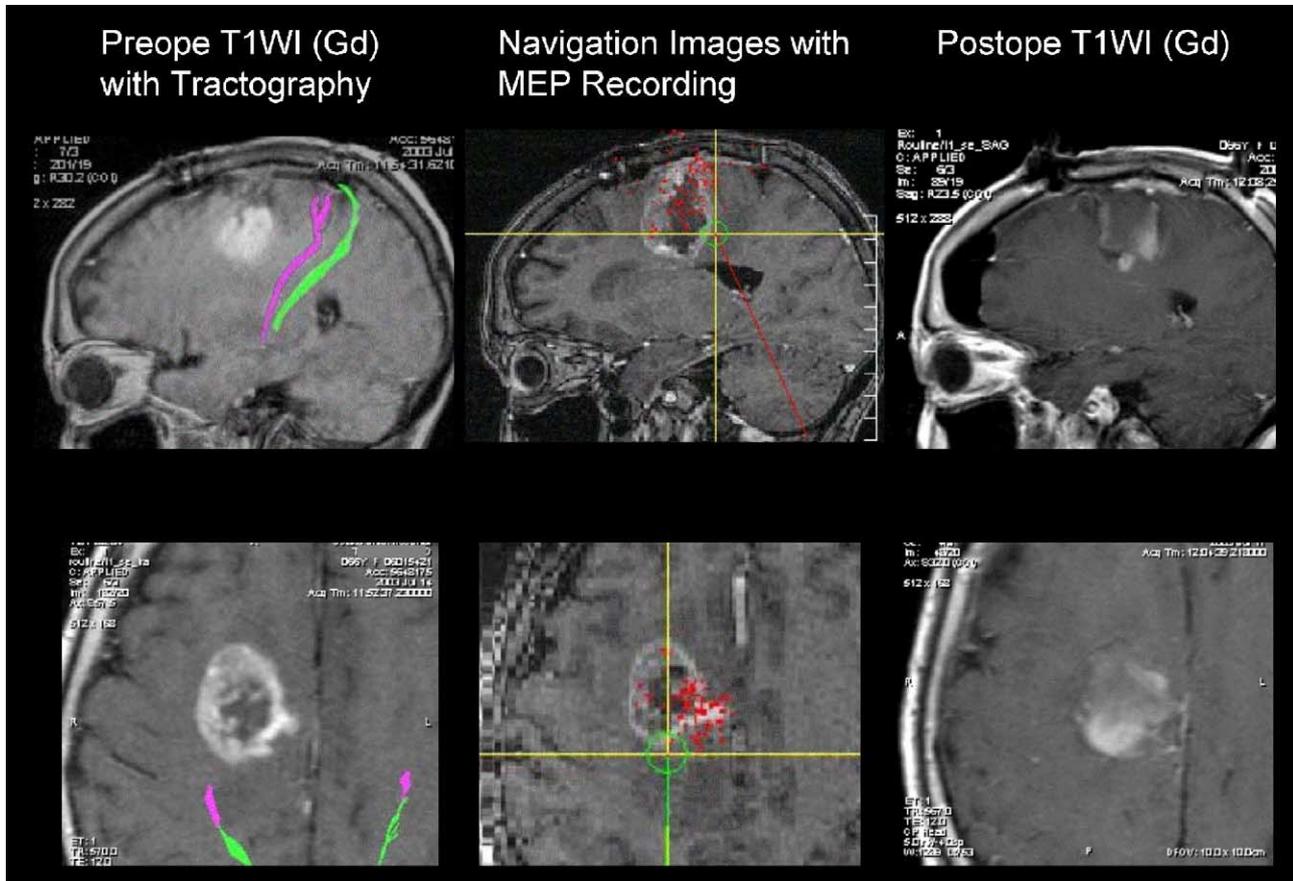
(Patient 1) MR images. Left row: preoperative sagittal and axial Gd-enhanced MR images with tractography. A ring-enhanced mass is identified at the right frontal lobe. Purple and green lines represent the pyramidal and sensory tract, respectively. Both appear to be located far behind the tumor. Middle row: images obtained intraoperatively with the CANS neuronavigation system. At the target, the intersection of the yellow lines, subcortical electrical stimulation elicited a positive response. Red spots show the track of the suction tube tip and identify the areas removed during surgery. Compared to the fiber-tracking images, the site where MEP was first recorded appears far anterior to the depicted pyramidal tract. Removal of a small amount of tissue from this area resulted in a dramatic reduction in the MEP response to electrical stimulation of the motor cortex. Right row: postoperative MRI confirming complete resection of the tumor. Reference to the fiber-tracking images suggests that there is sufficient distance from the pyramidal tract. However, this patient's left-sided hemiparesis worsened after surgery.
